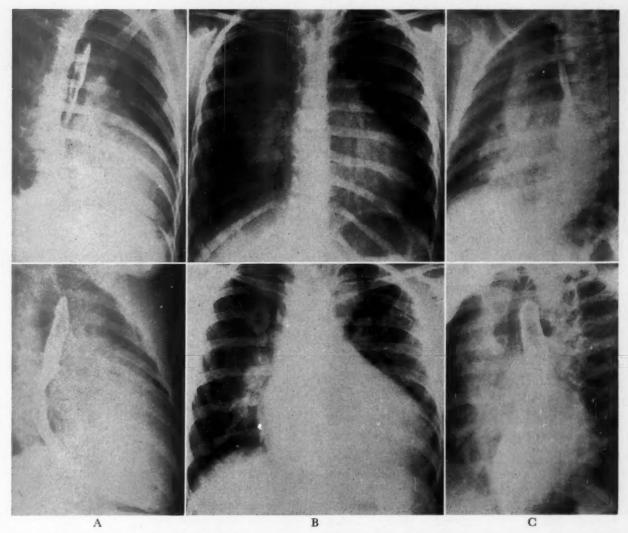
Case 48. Roentgenograms depicting ventricular septal defect with prolapsed aortic cusp. The films in lower row were taken seven years after those in upper row. Note the marked increase in the size of the left ventricle (B and C) and left atrium (A), the marked dilatation of the aorta (B and C) and the increase in pulmonary vascularity (B).
